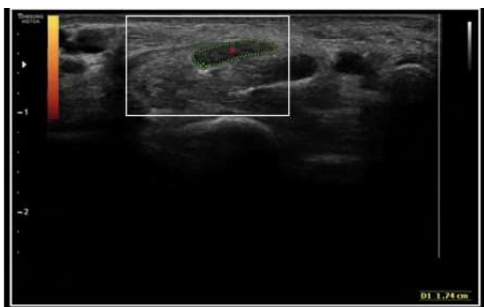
Intra Substance Vascularity of Median Nerve in NCS Positive Patient Using Doppler Scan
